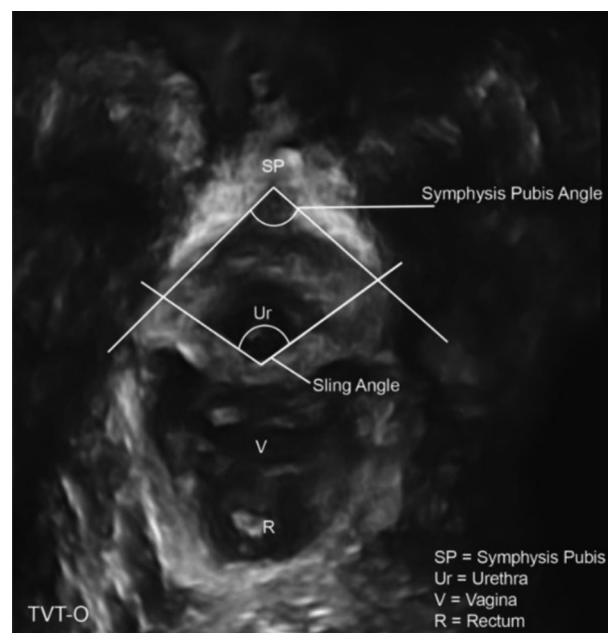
Coronal view of translabial ultrasound of the female urethra.
